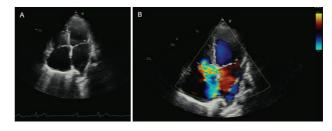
Apical 4-chamber views in (A) 2-D Imaging and (B) Color Flow Imaging display showing the dilated right cardiac chambers and left atrium, dilated tricuspid and mitral annuli, and severe TR
